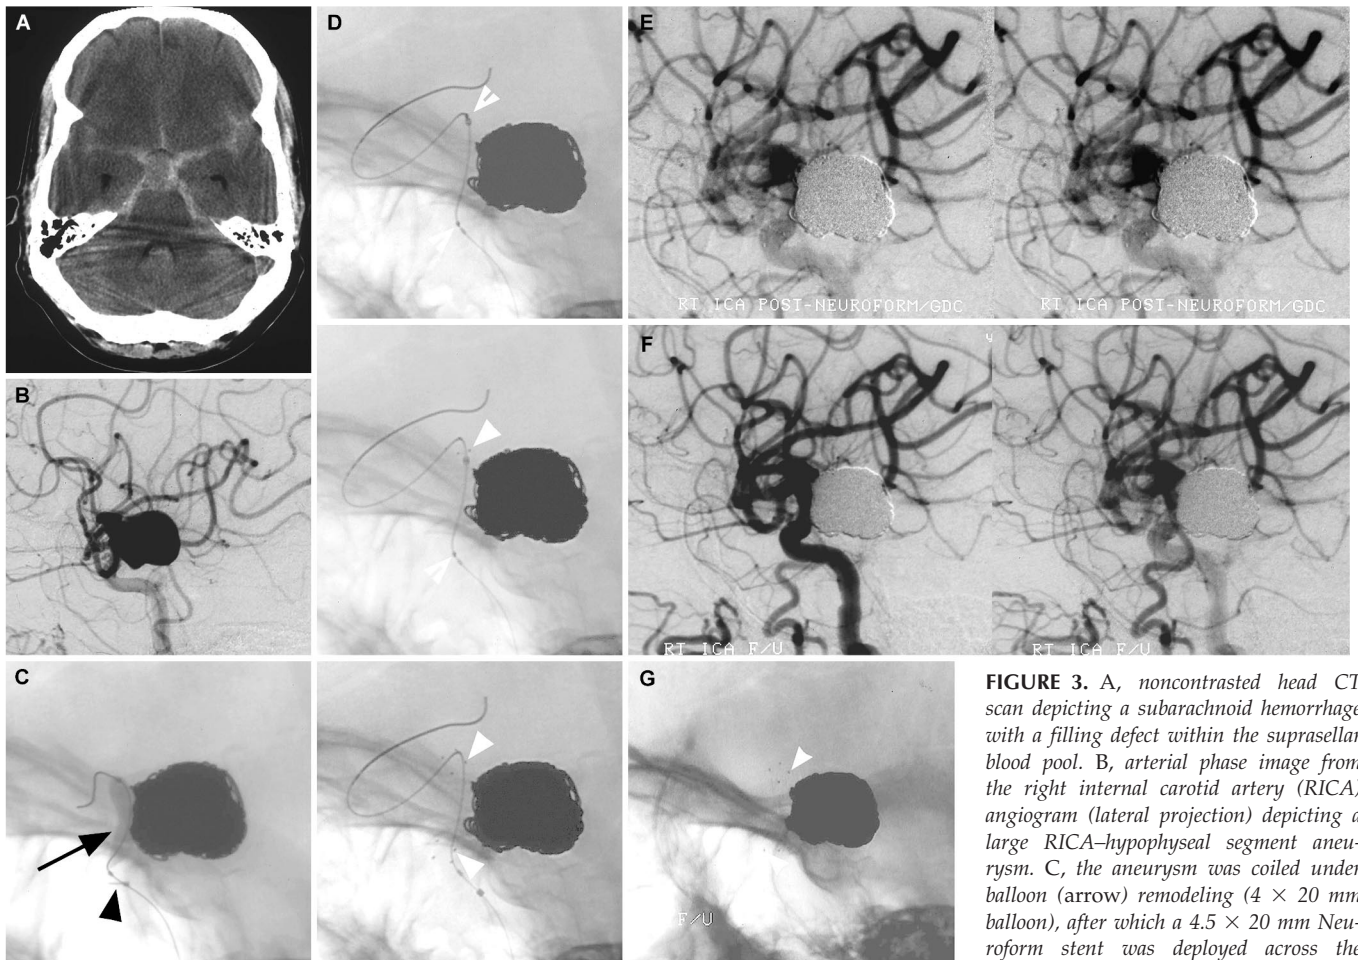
A, noncontrast head CT scan depicting a subarachnoid hemorrhage with a filling defect within the suprasellar blood pool. B, arterial phase image from the right internal carotid artery (RICA) angiogram (lateral projection) depicting a large RICA-hypophyseal segment aneurysm. C, the aneurysm was coiled under balloon remodeling (4 × 20 mm balloon), after which a 4.5 × 20 mm Neuroform stent was deployed across the aneurysm neck. D, three sequential
